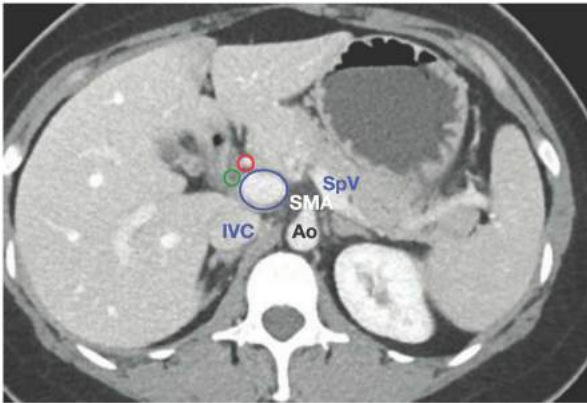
• Axial CT demonstrating the normal anatomic relationship of the bile duct (green circle), hepatic artery (red circle), and portal vein (blue circle). And they enter the hilum of the liver. Also labeled are the IVC, splenic vein (SpV), aorta (Ao), and SMA. This patient had a mass in the head of the pancreas.
